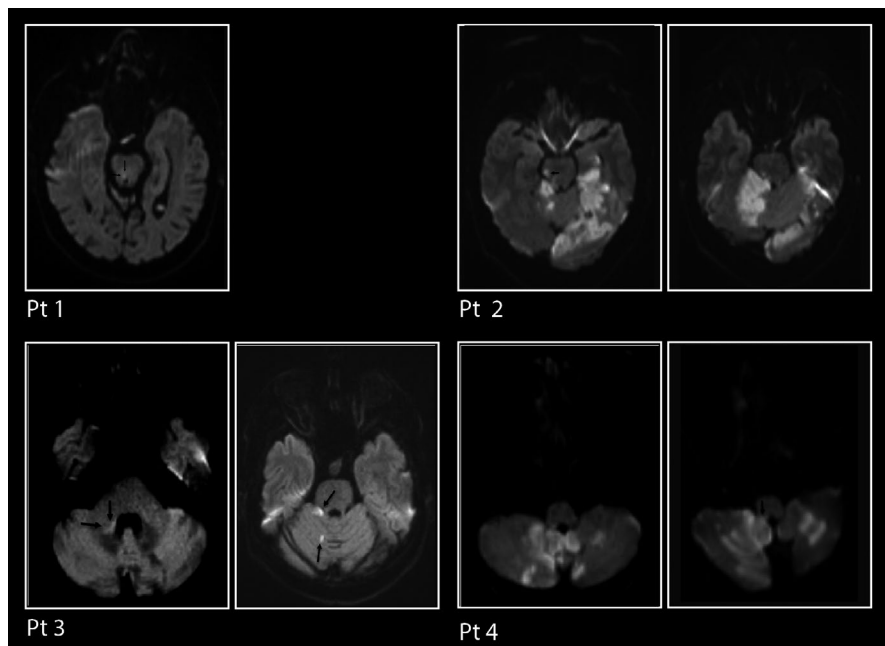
An MRI montage (axial MRI with diffusion-weighted imaging) of stroke lesions in four patients (Pt) with pathologic GEN. We chose representative image sections for each patient. Lesions were located in the right midbrain for Pt #1, in the right midbrain and right superior cerebellar peduncle, tectum and right tegmentum for Pt #2, in the right cerebellar hemisphere (lateral) and right middle cerebellar peduncle for Pt #3, and in both cerebellar hemispheres, the vermis and the right posterior inferior medulla involving the right medial and lateral vestibular nuclei for Pt #4
